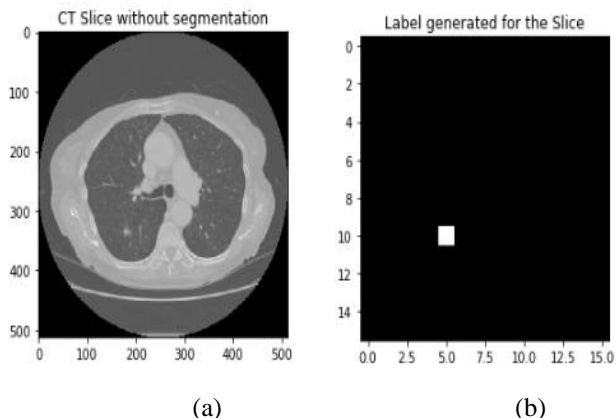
(a) Slice of CT scan (b) Generated label from the annotation given in XML files.
